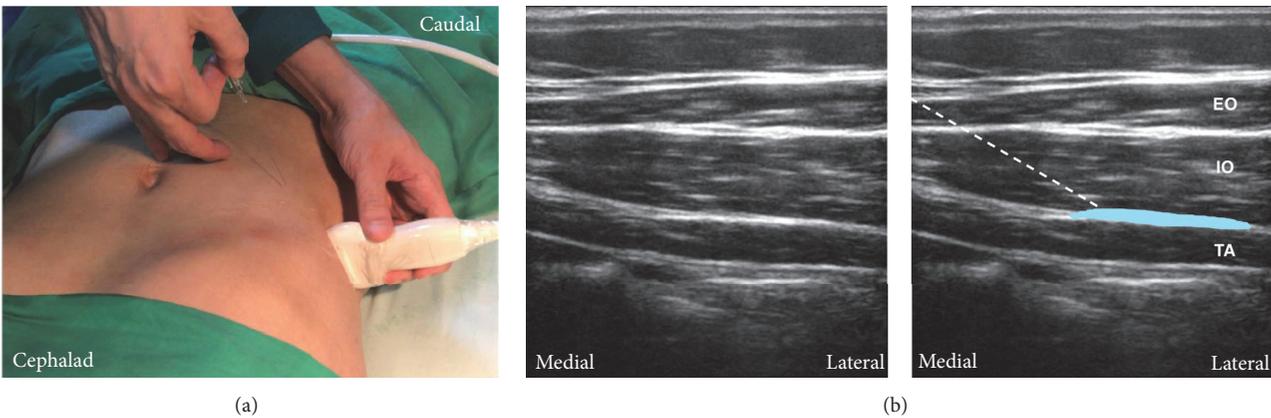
Lateral approach of transversus abdominis plane (TAP) block. (a) The probe position and needle trajectory. The probe is near or at the midaxillary line between the costal margin and the iliac crest. The needle is inserted in plane. (b) Corresponding ultrasound images. The TAP is between internal oblique and transversus abdominis. The local anesthetic is deposited in this plane to cover the lower TAP plexus. White dashed line: needle trajectory. Light blue area: the deposition site of local anesthetic. TA: transversus abdominis; IO: internal oblique; EO: external oblique.
